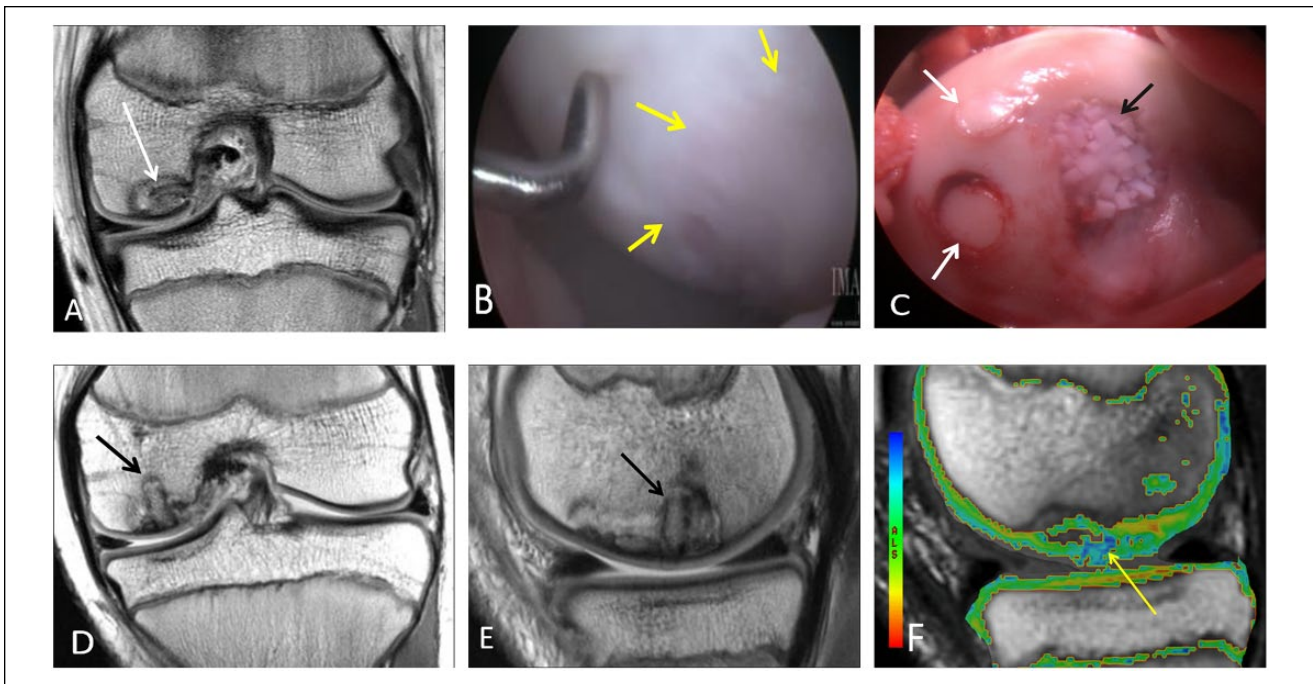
An 11-year-old male who had repair of an osteochondral lesion by osteochondral autograft transfer system (OATS) and de novo juvenile cartilage transplantation technique. Coronal (A) proton density-weighted TSE MRI shows a large unstable osteochondral lesion over the medial femoral condyle. (B) Arthroscopy view of the lesion over the central weight bearing surface of the medial femoral condyle. The arrows are outlining the edge of the osteochondral lesion. (C) Two OATS autografts placed in situ into the osteochondral lesion (white arrows). De novo particulate juvenile cartilage transplantation onto the medial femoral condyle lesion is seen (black arrow). Coronal (D) and sagittal (E) proton density-weighted TSE MRI 2 months later demonstrate partial bony incorporation of the osteochondral plug (black arrows). Note the presence of residual osteochondral lesion that is not covered by the single plug approach, closer to the intercondylar notch. This is noted lateral to the lesion in the coronal image (D) and anterior to the lesion in sagittal image (E). T2 mapping MRI (F) shows residual increased T2 relaxation values (yellow arrow) at the margins of the osteochondral transfer. Two years postoperatively, the patient is pain-free and returned to playing sports.
